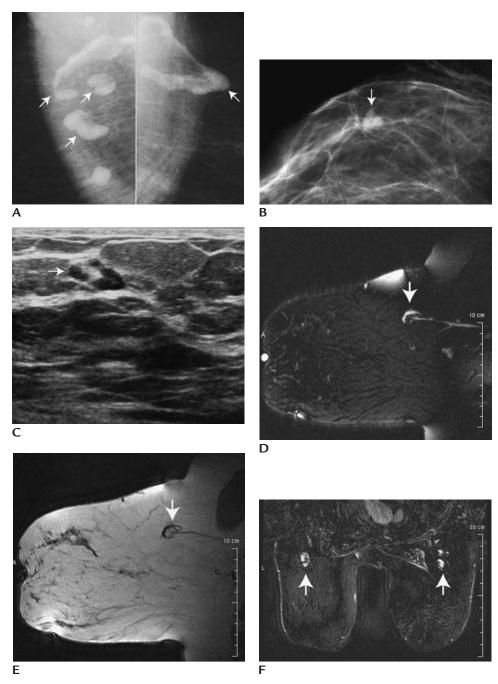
Lymph nodes. (A) Multiple masses (*arrows*) of mixed density right axilla, one in left axilla. No fatty hilum is apparent in two of the masses in the right axilla; however, these are unchanged compared with prior studies (not shown). Size and proportion of soft tissue to fatty hilum are variable. (B) Different patient. Lobular mass (*arrow*) with circumscribed margins. Lymph nodes can vary in size between examinations, sometimes going away completely only to reappear on subsequent studies. (C) Hypoechoic lobular mass (*arrow*) with central area of echogenicity (fatty hilum). (D) Different patient. Sagittal T2-weighted image, fat suppression. Lymph node (*arrow*) demonstrating bright signal intensity. Low signal intensity associated with fatty hilar region. Vessel (bright signal, linear) entering at hilar region. (E) Corresponding sagittal T1-weighted image. Lymph node (*arrow*). Low signal intensity. Bright signal from fatty hilar region; vessel entering hilar region. (F) Subtraction axial image. Several lymph nodes (*arrows*) demonstrating rapid initial enhancement and wash out of contrast bilaterally.
